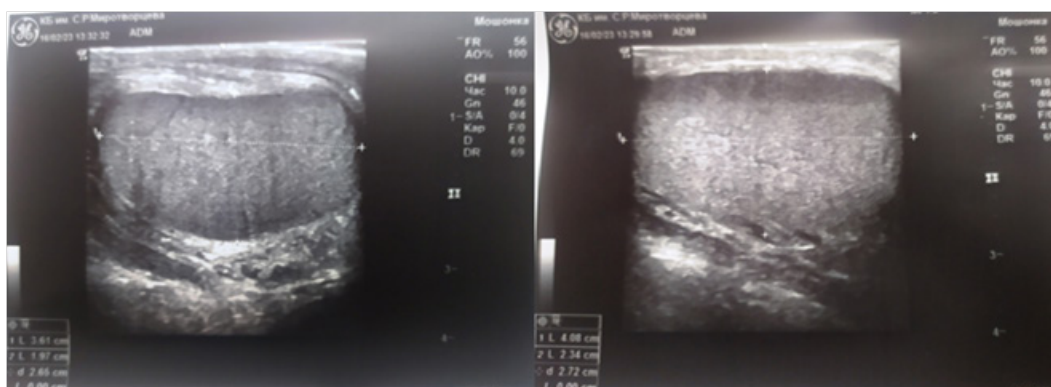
Ultrasonograms of the gonads of patient K. The testicles are reduced in size, the echostructure of their parenchyma is heterogeneous
